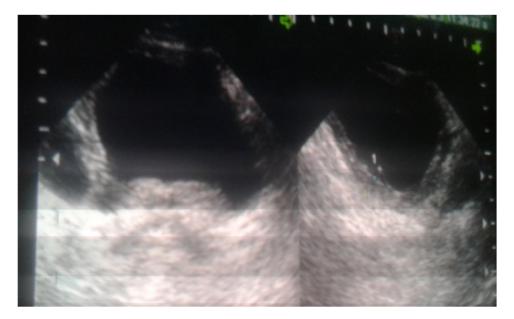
longitudinal and transverse sonogram male 22yrs of urinary bladder male shows focal thickening of posterior urinary bladder wall.
